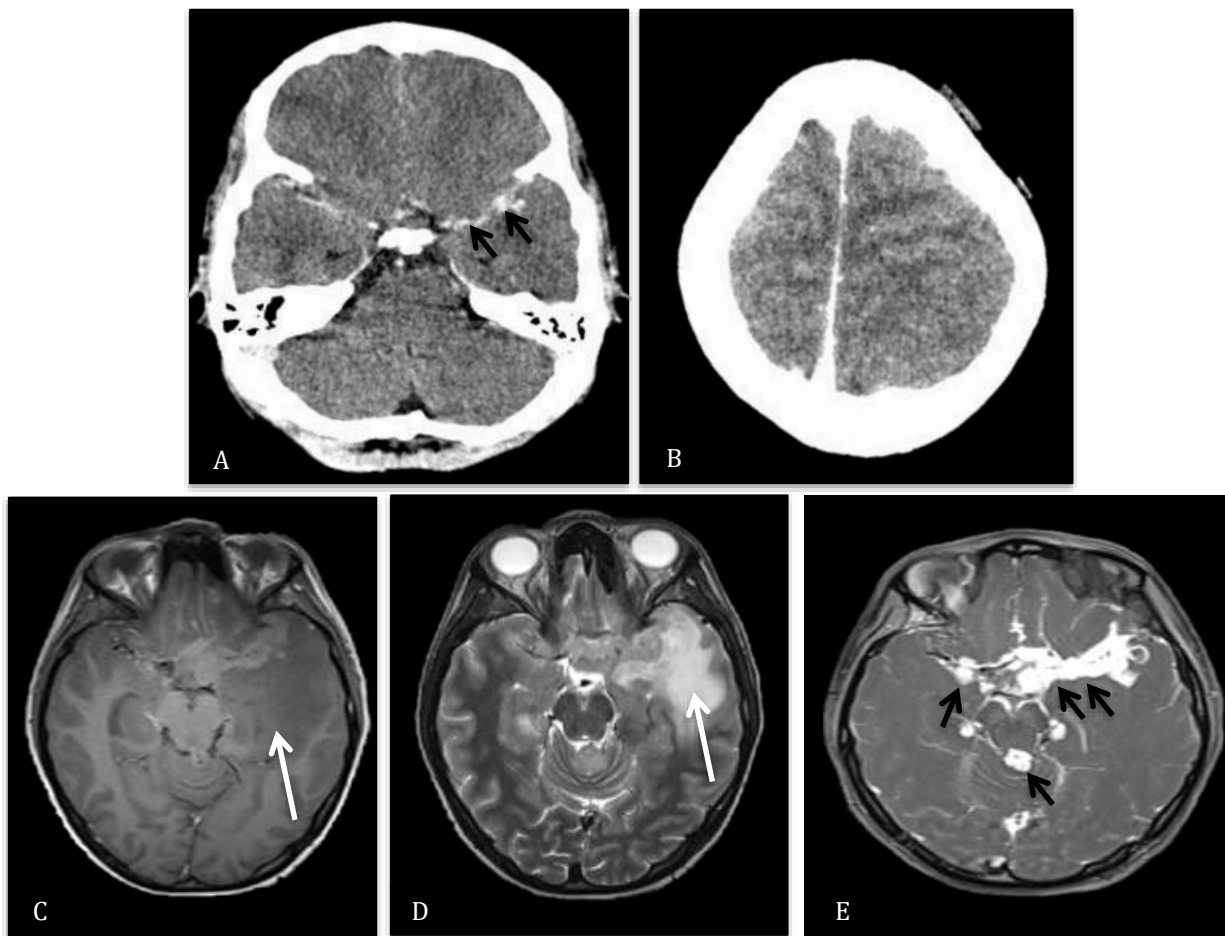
Case 3; 17/boy. (A-B) Contrast enhanced CT brain shows nodular enhancement within the left basal cistern (arrows) with associated generalized brain edema. (C-D) Axial T1W and T2W brain of the child show huge area of white matter edema in left temporal lobe (arrow). (E) Axial T1 post-gadolinium shows thick nodular enhancement of the basal cisterns along the course of middle cerebral artery bilaterally as well as in the ambient cistern posteriorly (arrows).
